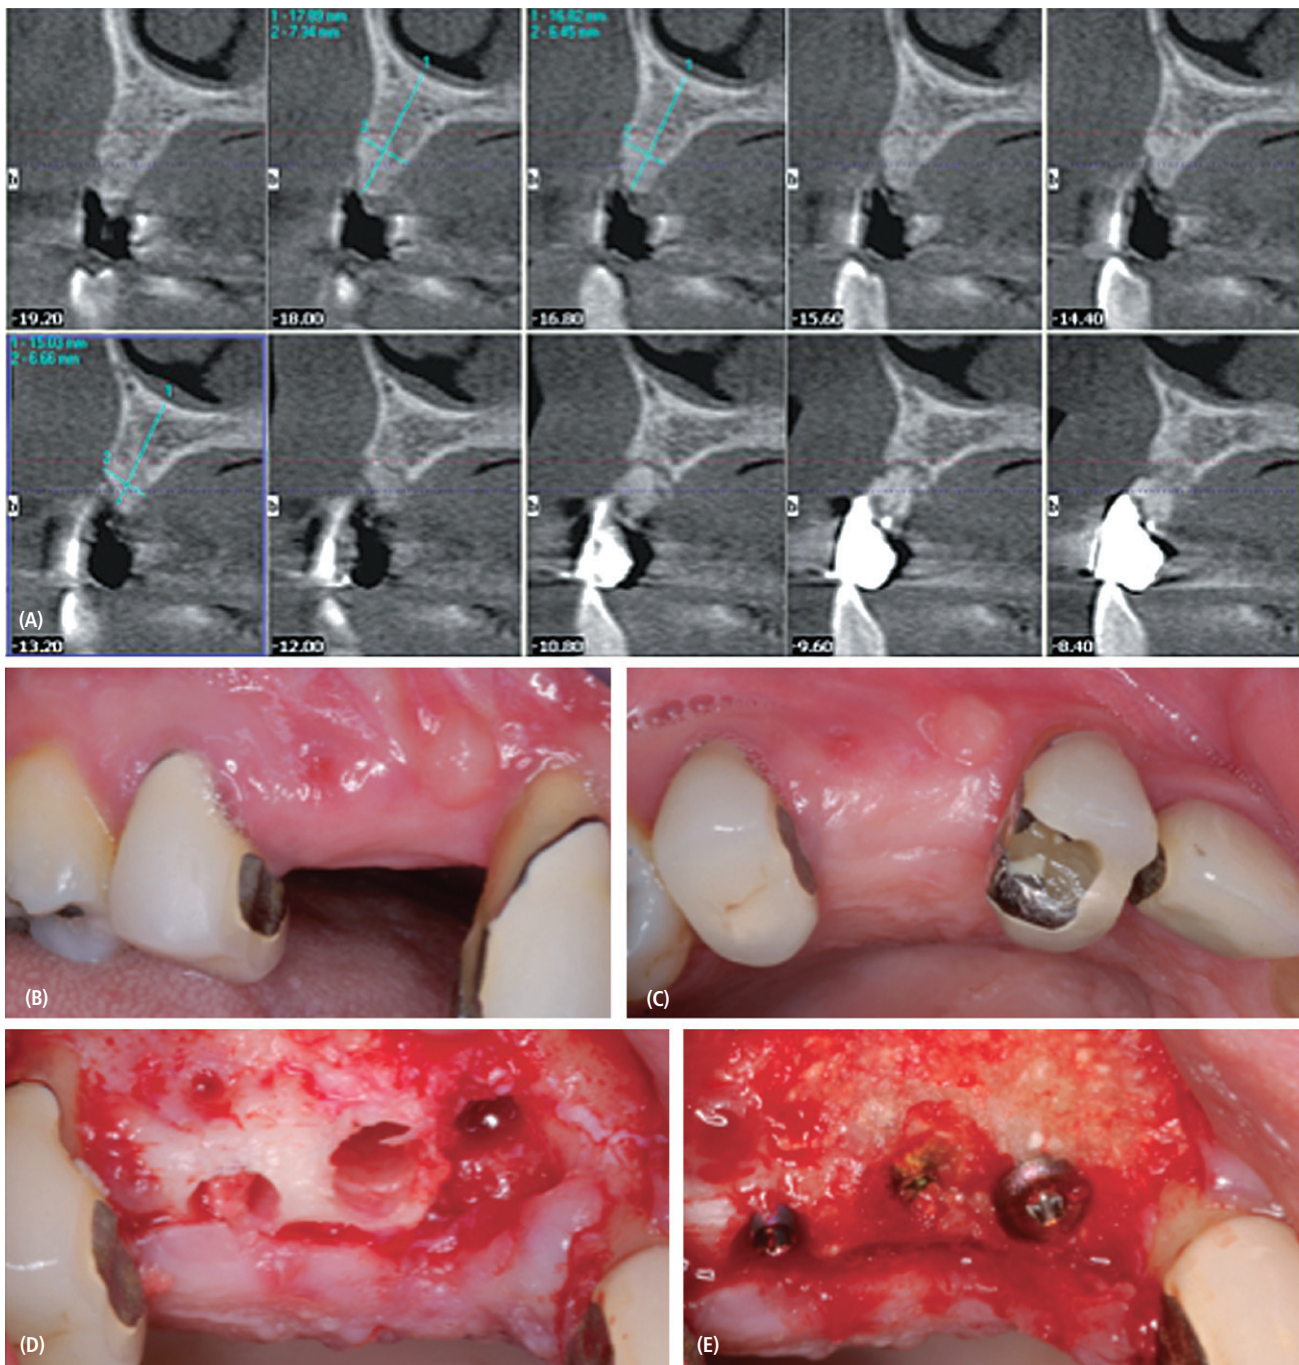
Surgical photographs and radiographs. A. CBCT slices of the implant site showing bone heights and widths (note in panel A that maximum alveolar bone height = 17.9 mm and width = 7.3 mm). B. Lateral view of the surgical site. C. Occlusal view of the surgical site. D. Post-extraction and implant sites. E. Implant placement (all implants were 13 mm long).
